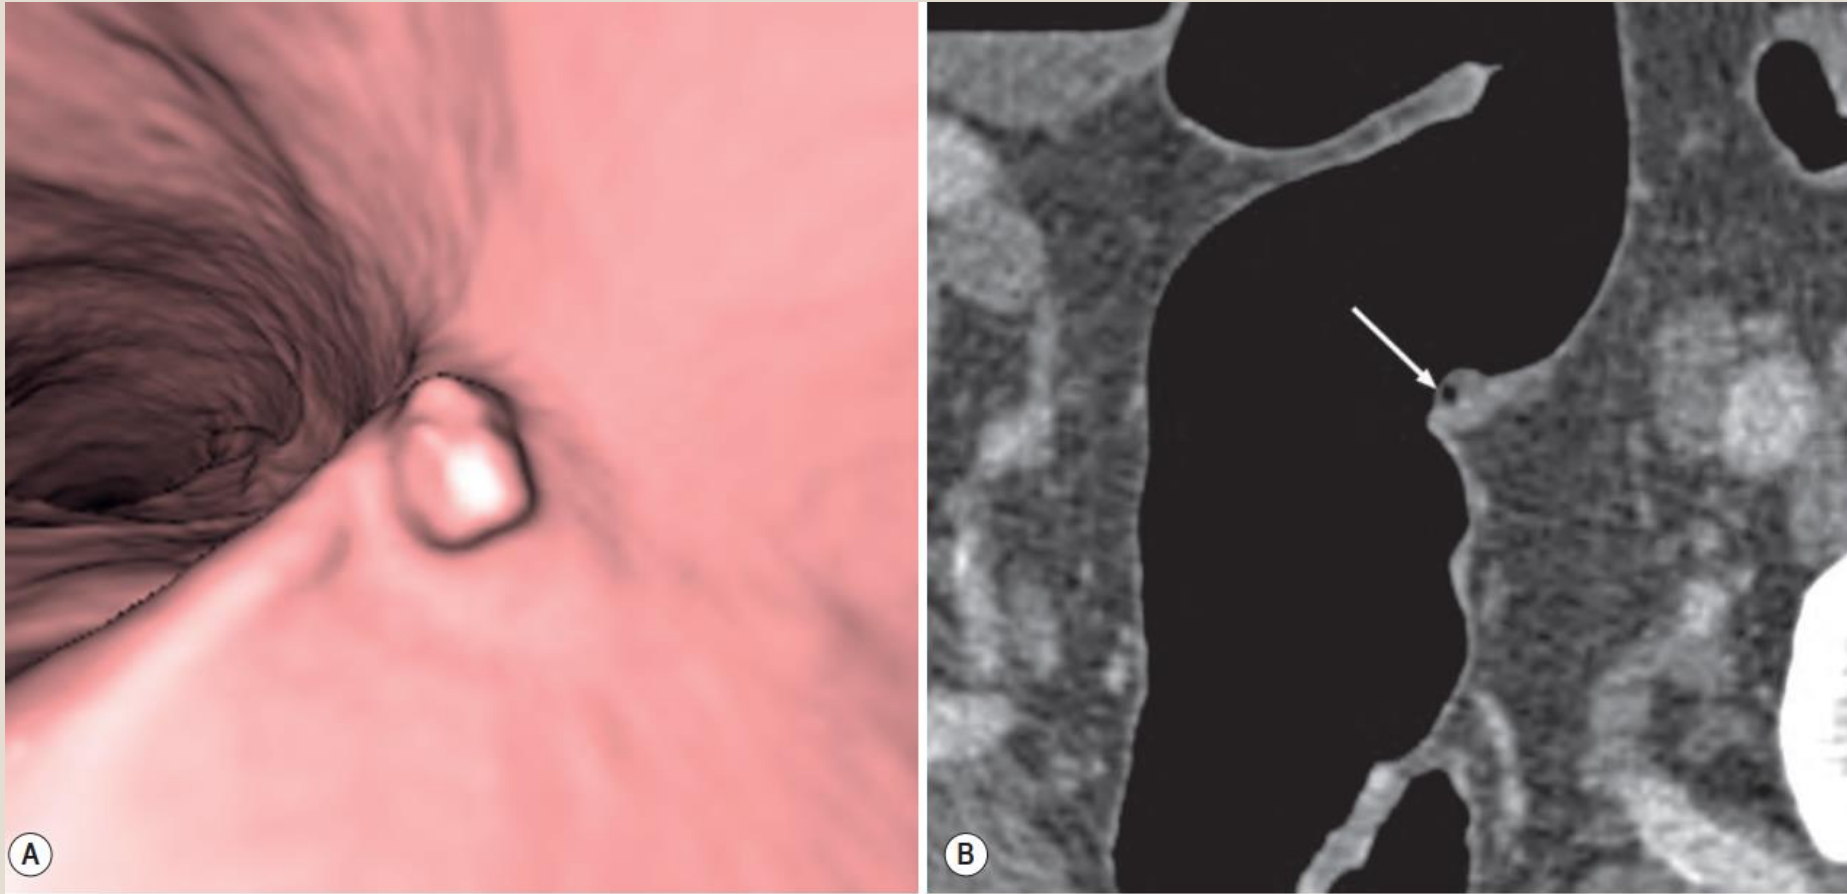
(A) 3D view from CT colonogram shows a polypoid lesion that might be mistaken for a sessile polyp. However, the 2D view (B) shows a tiny locule of gas (*arrow*), demonstrating that this is, in fact, retained faecal residue.
